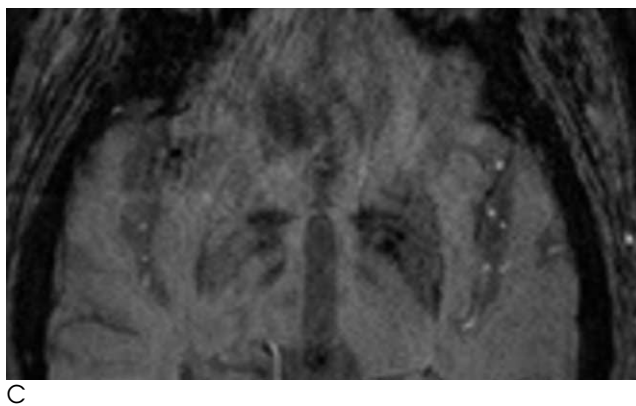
Loss of arterial bright signal intensity in sylvian fissure. Diffusion-weighted MR imaging (a) shows restricted diffusion area, representing acute infarction, involving right insular region. In the slice of more upper portion (b), restricted diffusion areas are also noted in the cortical and subcortical area. On magnified image of SWI (c), loss of tiny arterial bright signal foci are demonstrated in the right sylvian fissure as compared with the left side.
